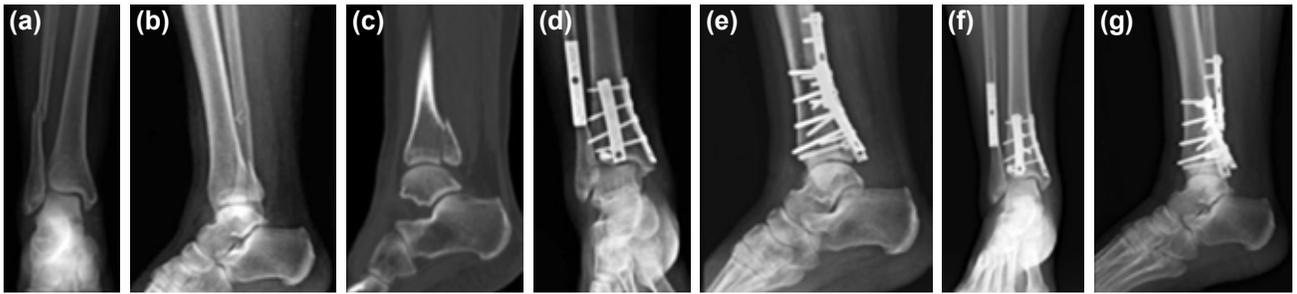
Posterior malleolar fracture treated with plate fixation (a) preoperative anteroposterior X-ray, (b) preoperative lateral X-ray, (c) preoperative sagittal section, (d) postoperative 6-month X-ray, (e) postoperative 6-month lateral X-ray, (f) postoperative 2-year X-ray, (g) postoperative 2-year lateral X-ray.
